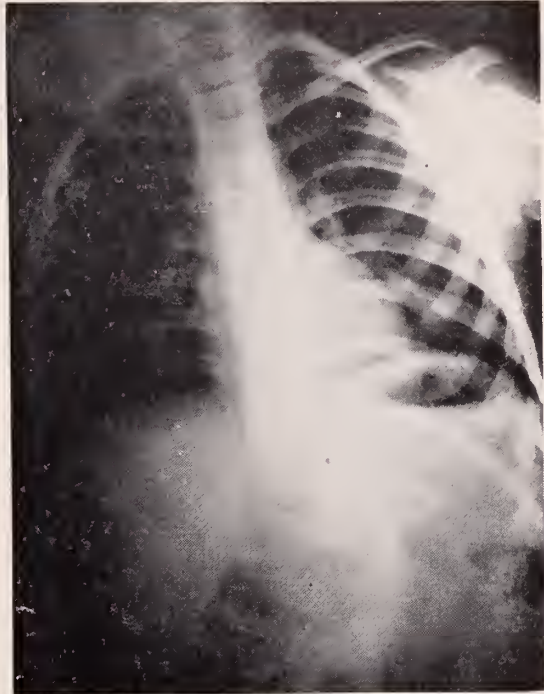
AP roentgenogram of Case No. 1 at age 5 years before ingestion of barium.
